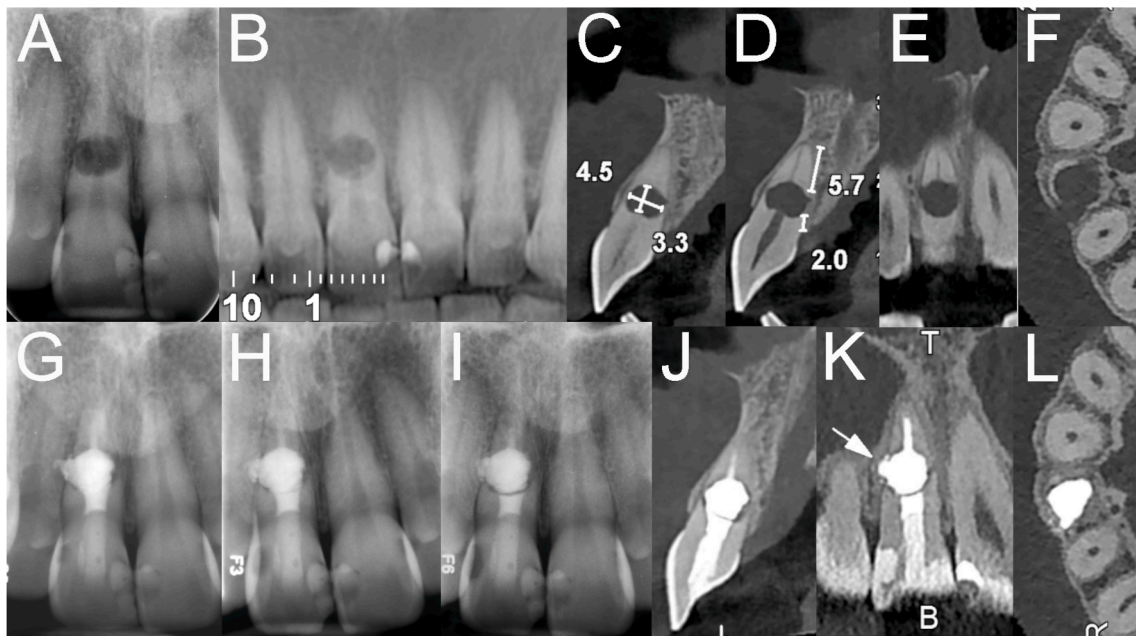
Radiographic and cone-beam computed tomography (CBCT) images of a maxillary right central incisor with extensive perforating internal root resorption (IRR) managed with orthograde bio-obturation using calcium-enriched mixture (CEM) cement. (A) Preoperative periapical radiograph showing an irregular radiolucency in the root canal space. (B–F) Preoperative (sagittal/coronal/axial) CBCT images confirming a large mid-root perforating IRR with communication to the periodontal ligament space. (G) Immediate postoperative radiograph demonstrating complete bio-obturation and limited CEM extrusion into the interdental bone adjacent to the lateral incisor. (H) One-year follow-up radiograph showing periradicular healing and a linear demarcation between the coronal bio-obtured defect and apical portion of the main root. (I) Three-year follow-up periapical radiograph confirming complete healing and stabilization. (J–L) Three-year CBCT scans showing a distinct demarcation line, stable obturation, and complete osseous integration of extruded CEM cement.
